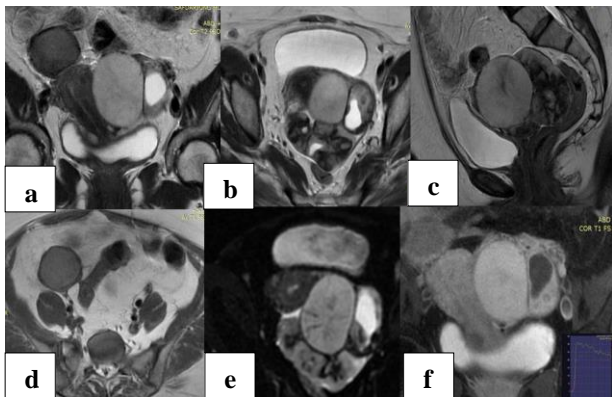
(a-c) MRI T2WI appearing hyperintense with central hypointense scar; (d) right sided lesion appearing hyperintense on T1WI; (e) absence of restricted diffusion; and (f) post contrast scan with heterogeneous enhancement.
